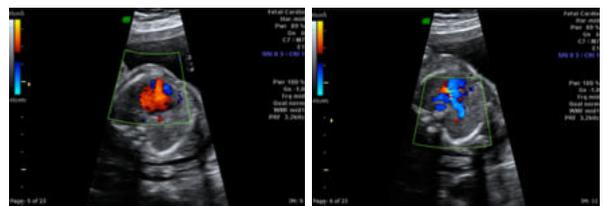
Doppler examination showing normal ventricles and RVOT
